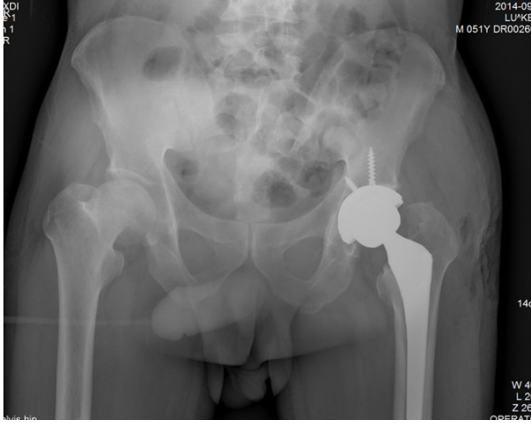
Plain radiograph after the first THA showed the implant in left hip.
